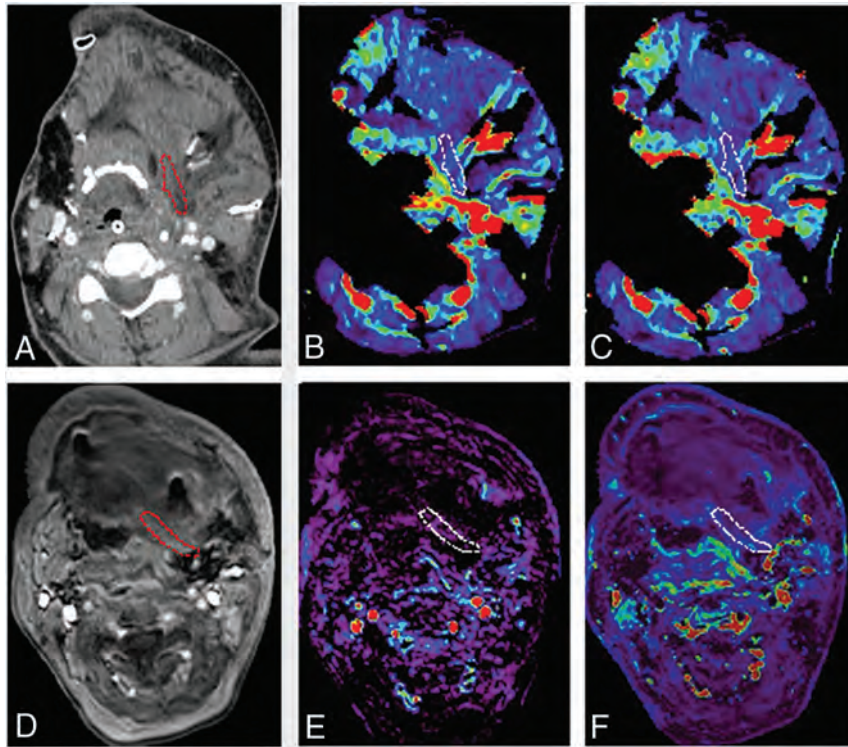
A 52-year-old woman with oral cavity squamous cell carcinoma was treated with mandibulectomy, glossectomy, tracheostomy, and neck dissection. A scapula free flap with latissimus dorsi was used to cover the soft tissue defect. The complication of venous congestion and ecchymosis was observed 2 days after the surgery. *A*, An ROI is placed within the junctional area of the free flap on contrast enhanced CT. *B*, Blood volume (mL/100 ml) and *C*, blood flow (mL/100 ml/min) are calculated and are 4.17 mL/100 ml and 11.3 mL/100 ml/min, respectively. *D*, An ROI is placed on the permeability map within the junctional area of the free flap and DCE-MR imaging parameters are calculated. *E*, Vp and *F*, K^{trans} (minute⁻¹) are 0.03 and 0.15 (minute⁻¹), respectively. Red and white circled areas represent region of interests.
